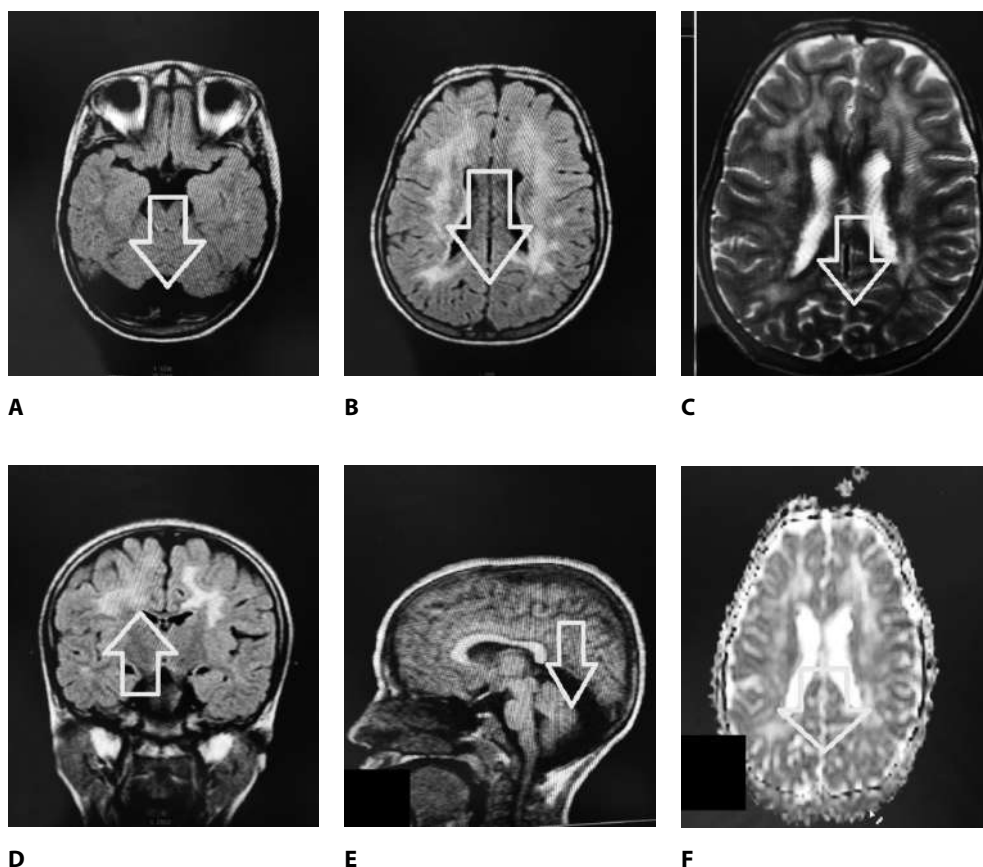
8-years-old boy with speech delay (Leukodystrophy: is genetic diseases that predominantly affect the white matter of the central nervous system): A. T1WI axial: isointense white matter lesion. B. FLAIR axial: deep white matter / bilateral periventricular hyper intensities. C. T2WI axial: bilateral periventricular deep white matter hyper intensities lesion. D. FLAIR coronal: hyper intensities deep white matter lesion. E. T1WI sagittal: isointense lesion. F. DW ADC map: non restricted diffusion deep white matter lesion
